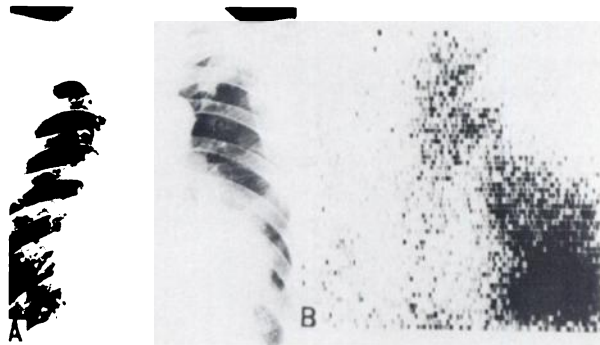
(A) Chest x-ray shows dense and diffuse shadows in left lower lung. (B) Scintigram is clearly positive.
